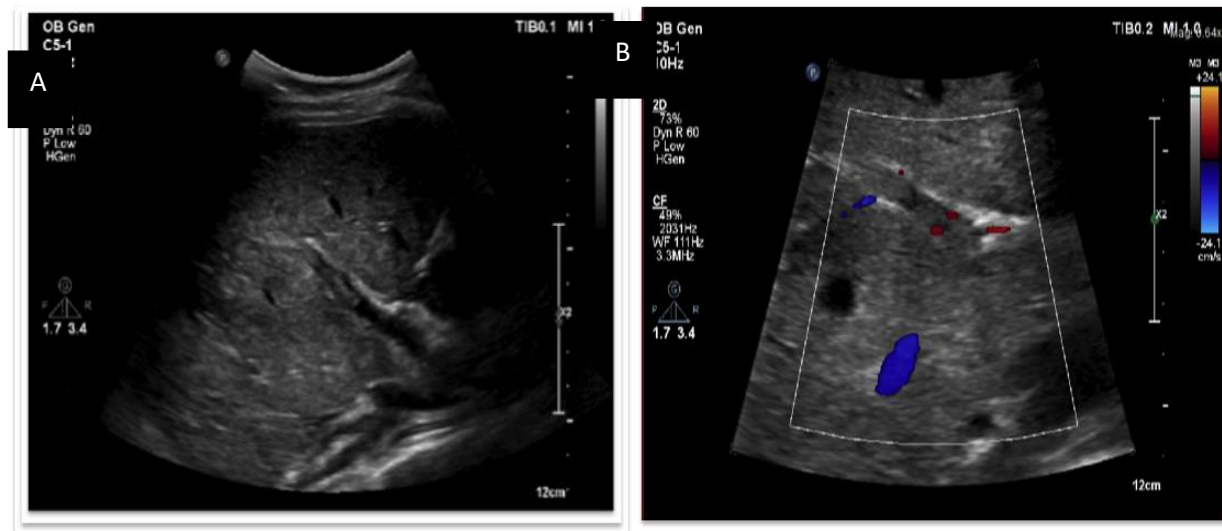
Doppler ultrasound of the abdomen. A) Left portal vein thrombus with a diameter of 11 mm. B) No blood flow is seen.
